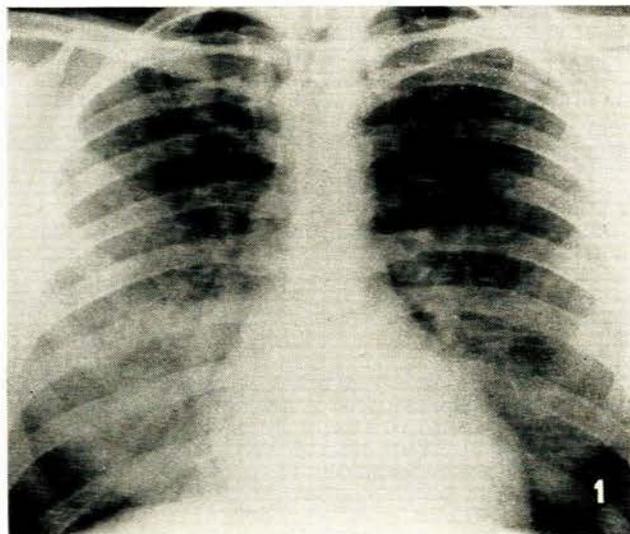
Chest X-ray showing bilateral diffuse perihilar opacities.
